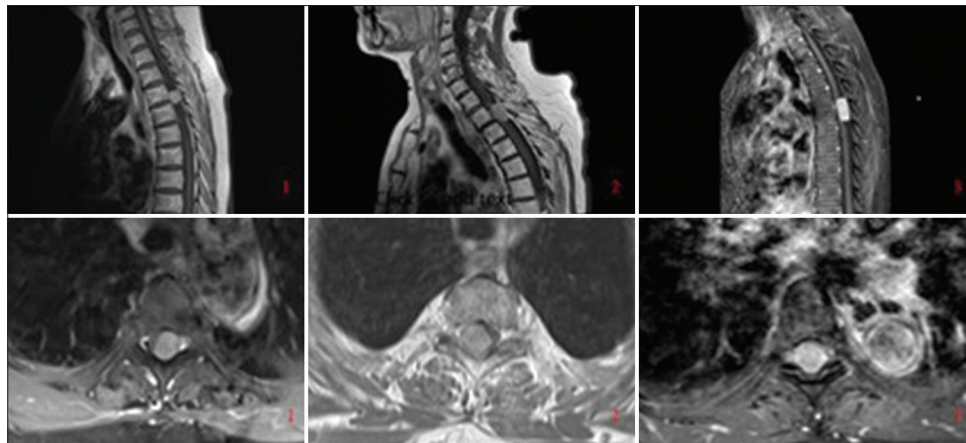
The sagittal and axial view of meningiomas in gadolinium-enhanced magnetic resonance imaging.
